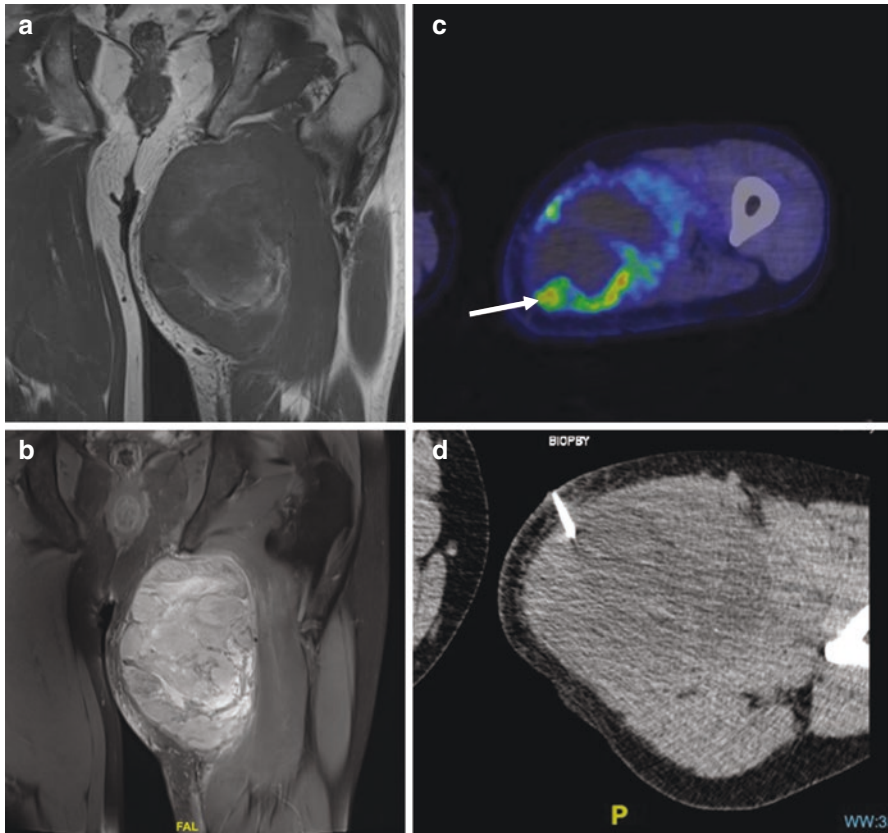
(a) T1 coronal view of large adductor sarcoma. (b) Fat saturation proton density coronal image of large adductor sarcoma. (c) PET image of adductor sarcoma demonstrating central necrosis with focal activity along the periphery of the tumour. Metabolically active tumour targeted for biopsy (white arrow). (d) CT-guided biopsy of targeted tumour with high metabolic activity and avoiding area of central necrosis
